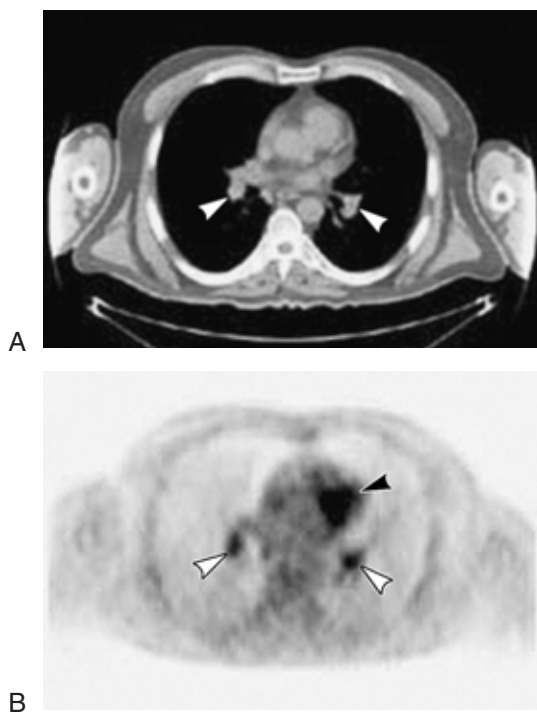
(A) CT of thorax showing soft tissue masses (lymphadenopathy – white arrowheads) adjacent to the pulmonary vessels. (B) PET scan at the same axial level showing increased metabolic activity (white arrowheads). Note high metabolic activity within the left ventricle (black arrowhead).
